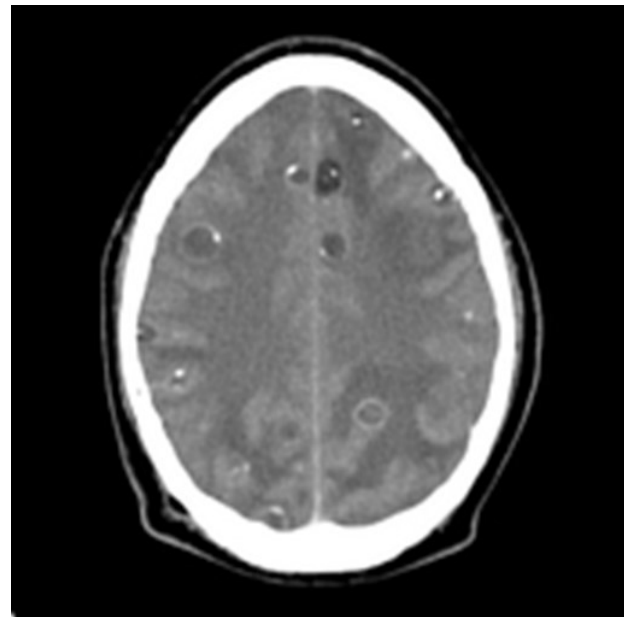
CT brain scan pathognomonic for neurocysticercosis: multiple ring and dot lesions.
